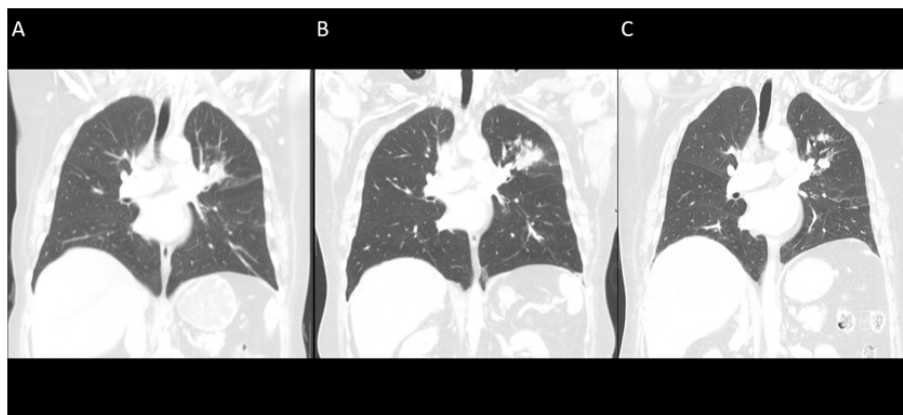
A. This radiologic abnormality was initially detected during a health check-up. B. Despite tuberculosis treatment, the follow-up CT scan showed an increase in the size of the lesion. C. After receiving praziquantel treatment, the patient showed improved clinical outcomes during regular outpatient visits.
